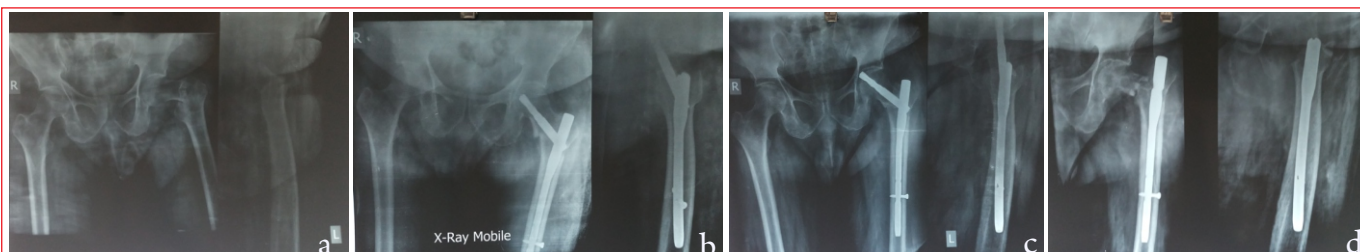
3a: 77-years male with AO 31A2 of left hip, 3b: He was treated with CRIF with Short CMN, 3c: Follow-up radiograph at 2 months showing proximal migration of helical blade, 3d: Helical blade removal was done at this stage
